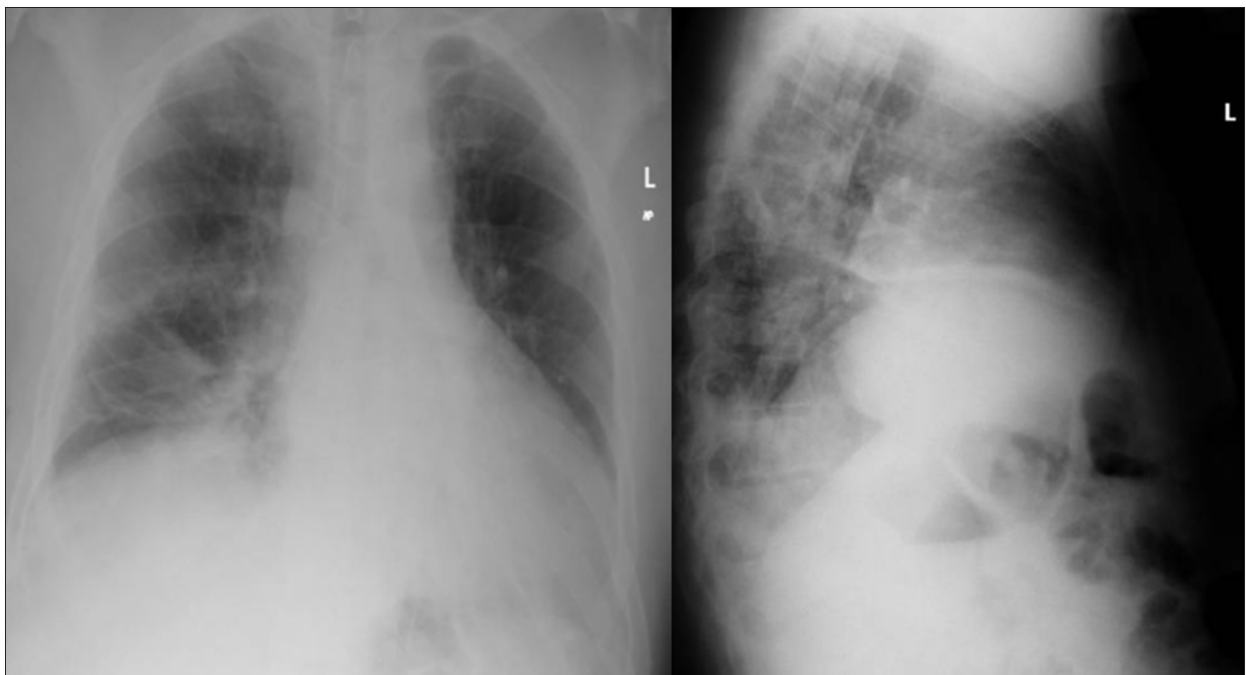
Chest X-rays performed on the day of discharge after clinical improvement. Posteroanterior and lateral chest X-ray performed the day of discharge showing resolution of the right pneumothorax. Additionally, the resolution of the previously observed subcutaneous emphysema is noted. Streaky right lower lung subsegmental atelectatic strands are also noted.
